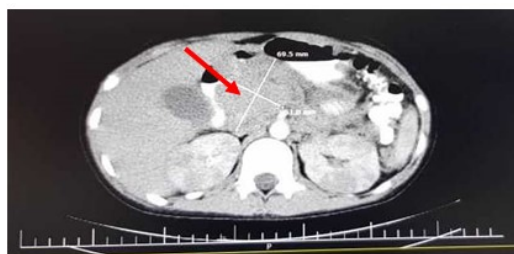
Abdominopelvic CT scan (para-pancreatic mass)
